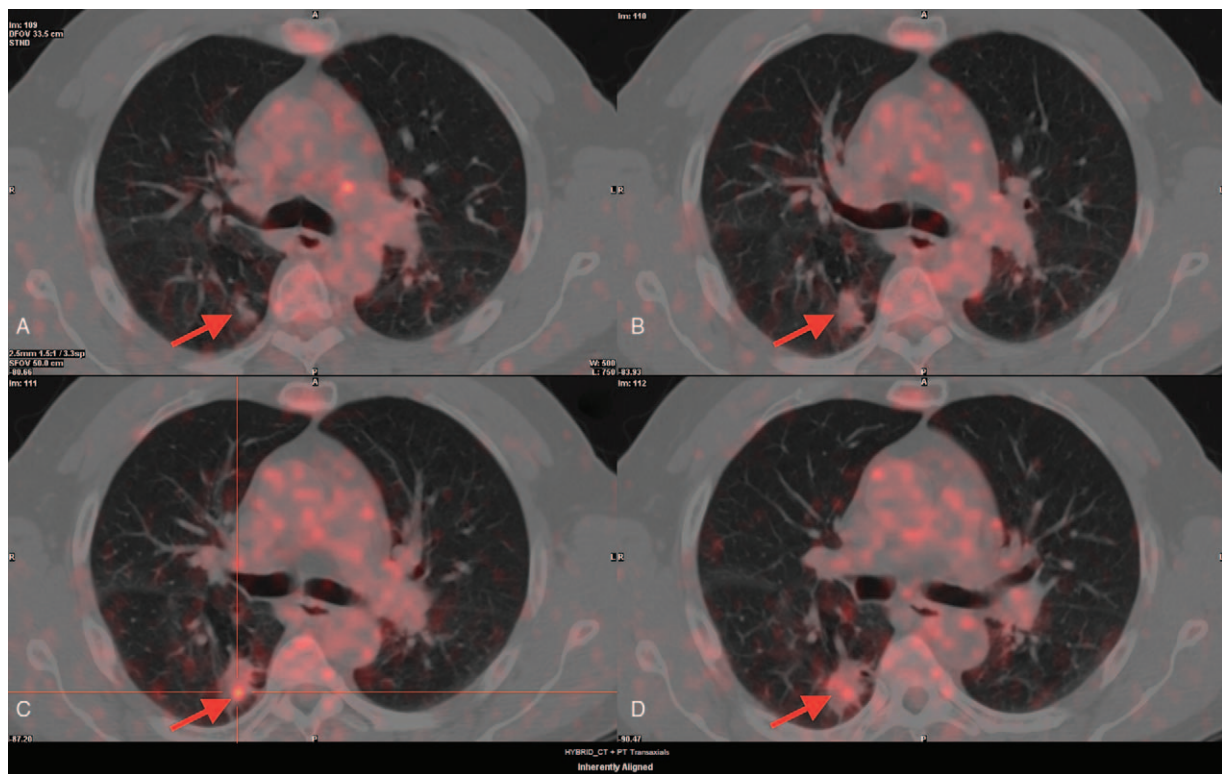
^{18}F FDG PET-CT revealing a pulmonary nodule with a moderately increased FDG uptake in the apical part of the right inferior lobe ($\text{SUV}_{\text{max}} = 4.4$) (red arrow on sub-images A–D). ^{18}F FDG = ^{18}F -Fluorodeoxyglucose, PET-CT = positron emission tomography–computed tomography, SUV_{max} = maximum standard uptake value.
